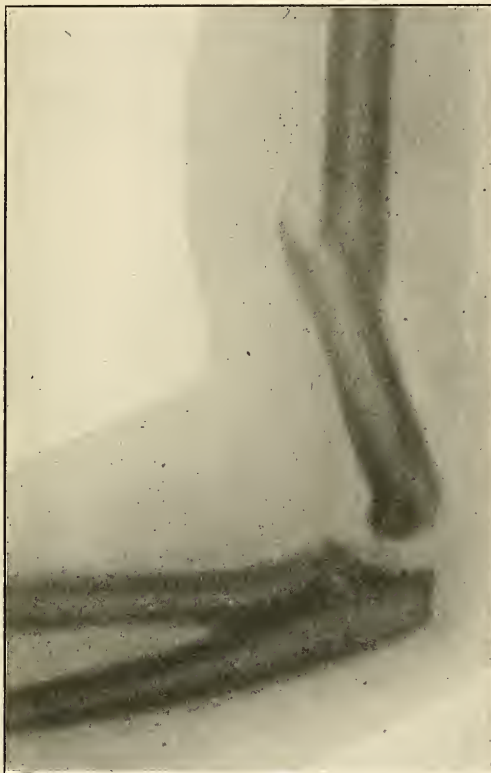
X-ray showing fracture of the humerus. (Ashhurst.)
